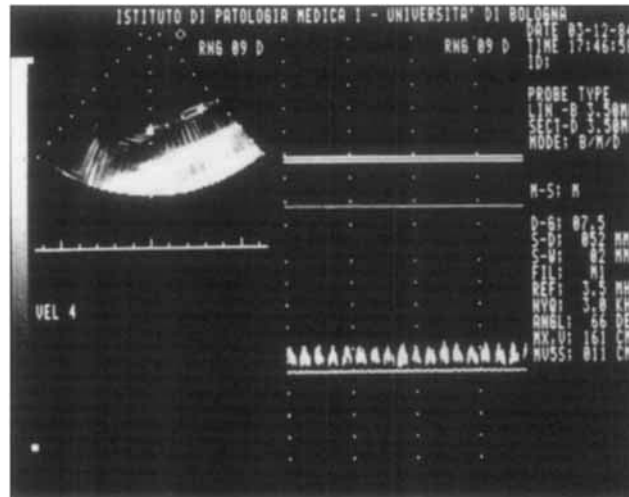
Echo-Doppler measurement of blood velocity in the silicon tube filled with human blood during the in vitro experiment of validation.
